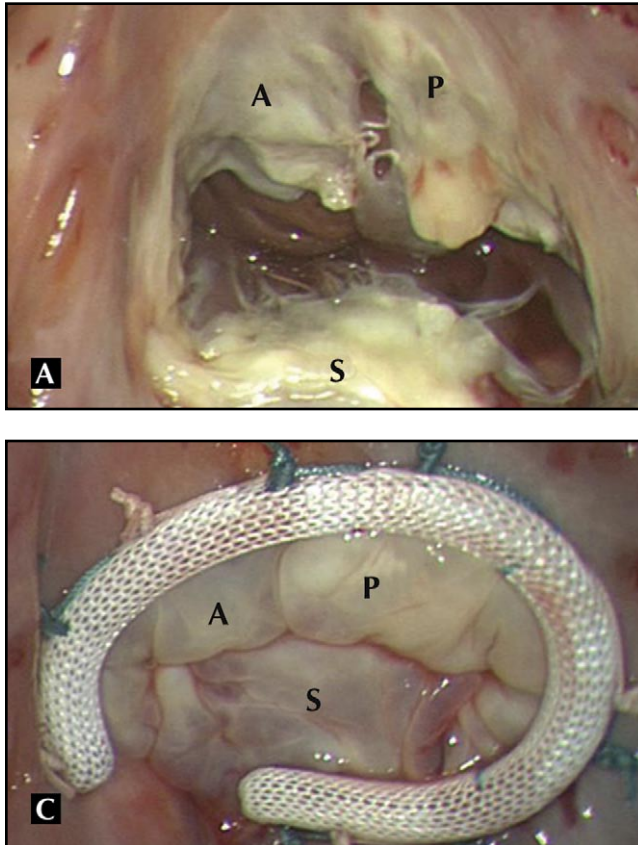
Tricuspid annular dilatation in a patient undergoing mitral valve repair. A, The tricuspid valve has been exposed through the right atrium. The annulus is grossly dilated with the three leaflets splayed apart. B, A sizer has been placed that represents the expected size of the valve annulus that should correspond to the area of the leaflets. The annular circumference is at least double that of a normal valve. C, An annuloplasty ring has been placed that corresponds to the area of the sizer in B. Excellent coaptation of the leaflets has been restored. This patient did not have any tricuspid regurgitation seen on her preoperative echocardiogram. A—anterior leaflet; P—posterior leaflet; S—septal leaflet.
